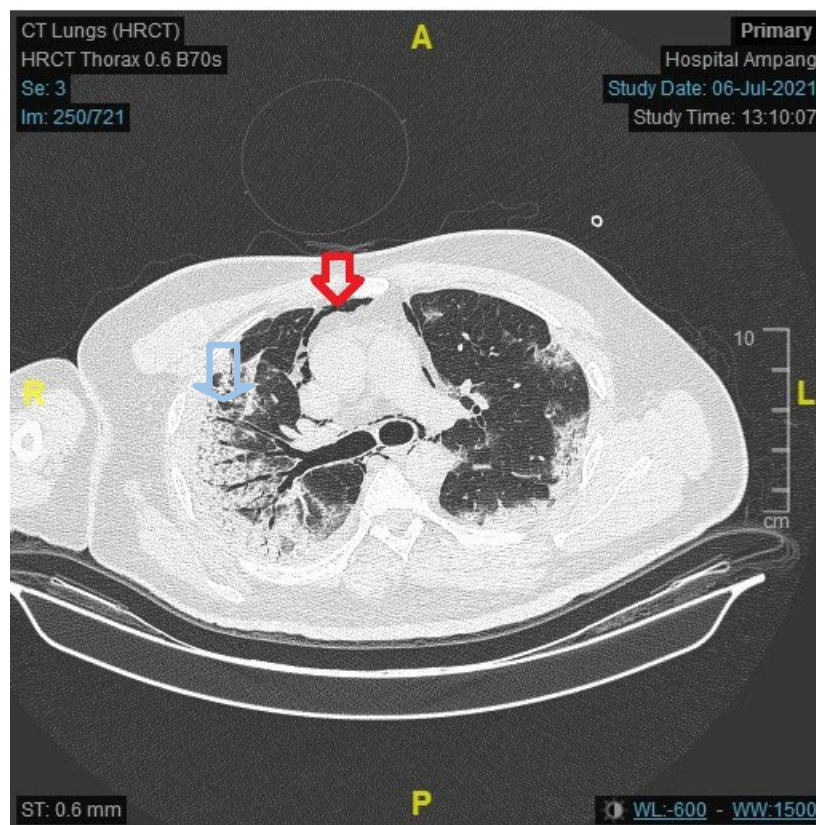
Axial CT revealing subcutaneous emphysema with pneumomediastinum (Red arrow) and GGO with consolidation.
